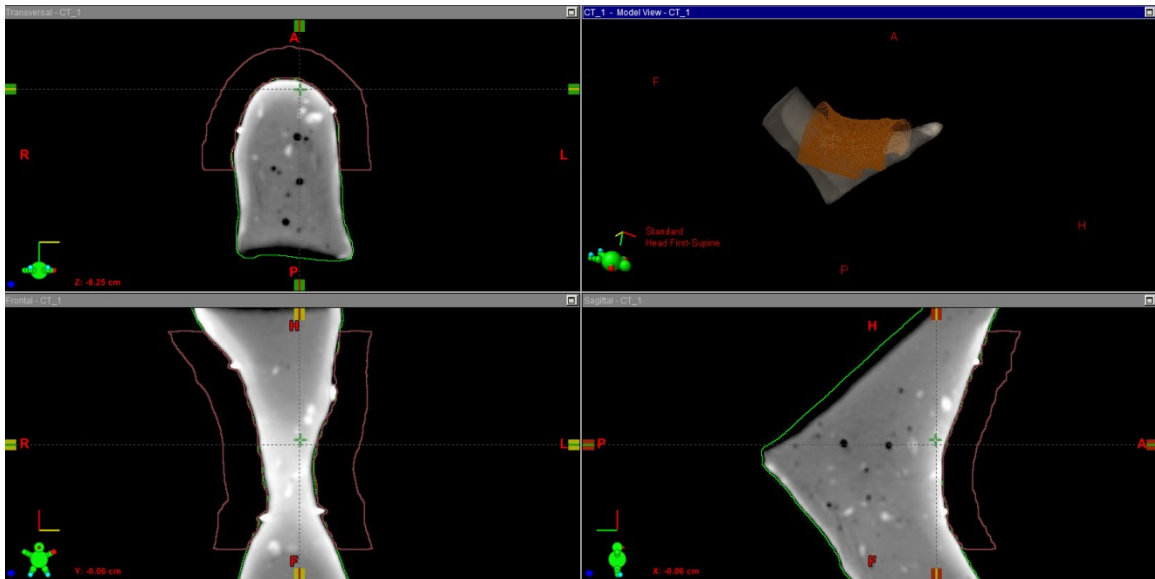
Creating the applicator in Eclipse. White points on the surface represent CT tape delineation of the tumour.
